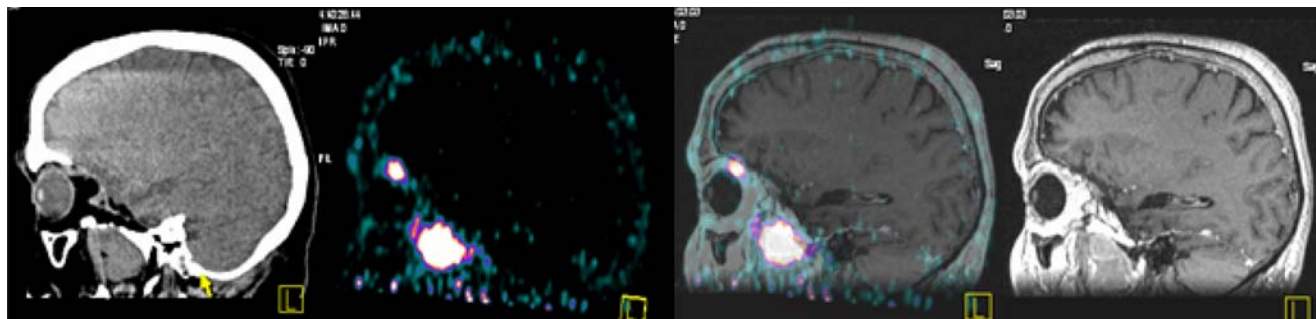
A 63-year-old male patient (pat. No. 5) with multifocal meningioma. MRI and PET/CT showed a recurrent tumour at the base of the skull 2 years after the resection. ^{68}Ga -DOTATOC-PET showed an additional intra-orbital lesion that could not be detected with Gd-enhanced MRI
